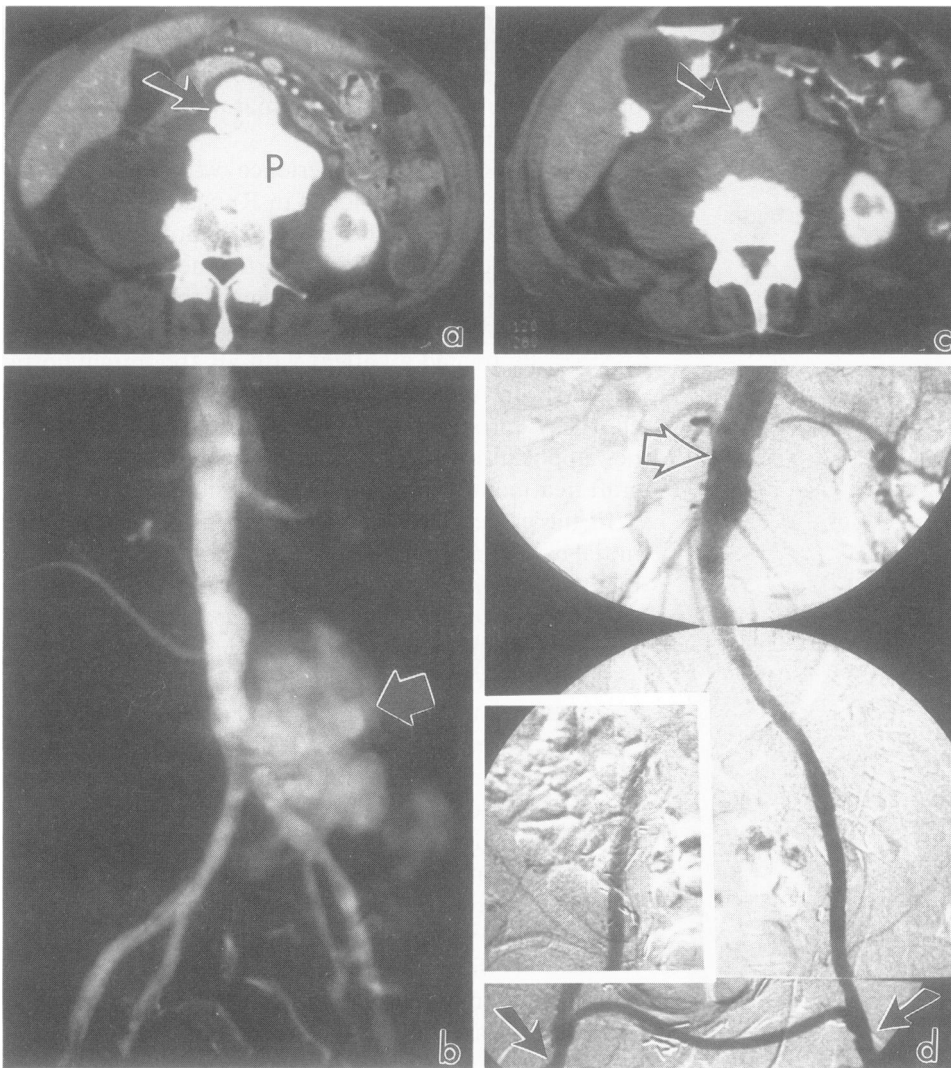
Transfemoral repair of a contained rupture of the distal aorta. (a) A spiral CT scan demonstrates extravasation of contrast material from the aorta (arrow) into a large, partially clot-filled pseudoaneurysm (P). (b) A transfemoral arteriogram confirms the presence of the large aortic pseudoaneurysm (arrow). (c) A spiral CT scan performed after transfemoral insertion of an endovascular graft demonstrates that the pseudoaneurysm is thrombosed, and vascular continuity within the lumen of the aorta (arrow) is preserved. (d) A postoperative transfemoral arteriogram at 1 week demonstrates vascular continuity between the aorta (open arrow) and the common femoral arteries (arrows).
